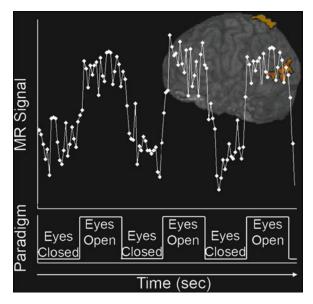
Functional MRI time course (*top graph*) representing the activation in the tertiary visual areas while a patient was instructed to close and then open their eyes in blocks of 20 s.
